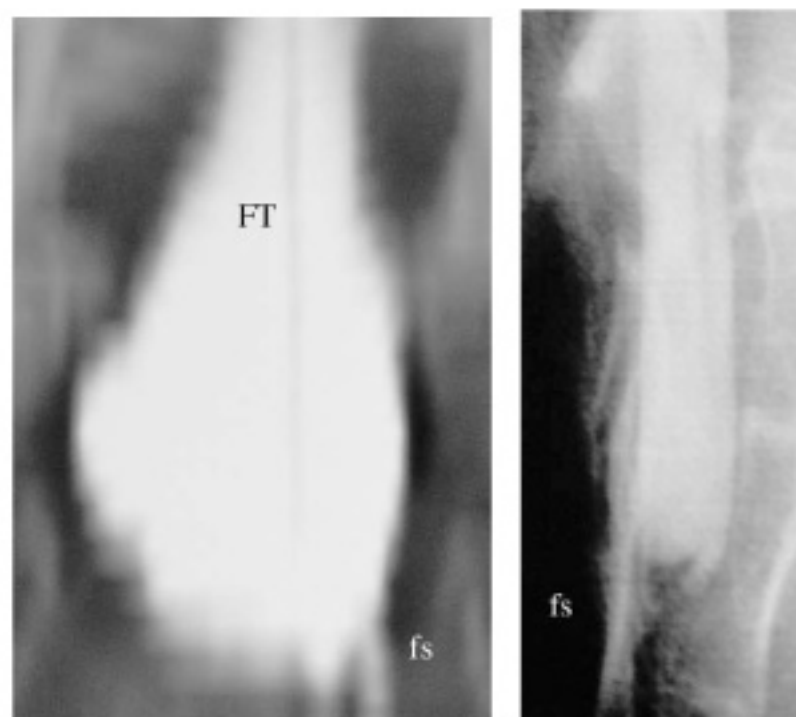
Case 11. Myelo-CT scan shows the filum terminale (FT) at the lumbosacral level with enlargement of the cauda equina and leak of contrast through a sacral fissure (fs). Anteroposterior view (left) and lateral view (right)
